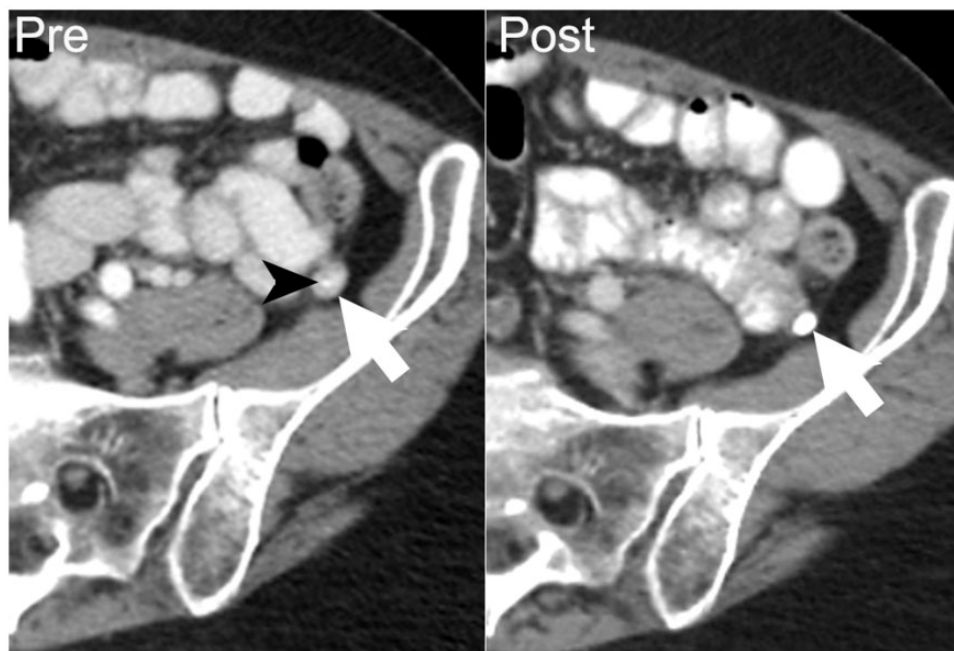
A 67-year-old woman with papillary serous ovarian adenocarcinoma. Axial contrast-enhanced CT performed at the start of chemotherapy shows an enhancing soft-tissue nodule in left paracolic gutter (arrow on left) with a punctate focus of calcification (arrowhead), compatible with a peritoneal implant. After 8 months of chemotherapy, follow-up contrast-enhanced CT demonstrates increased density of the calcification and decreased size of the left paracolic gutter nodule (arrow on right), indicating that increasing density of calcification may be associated with a treatment response.
